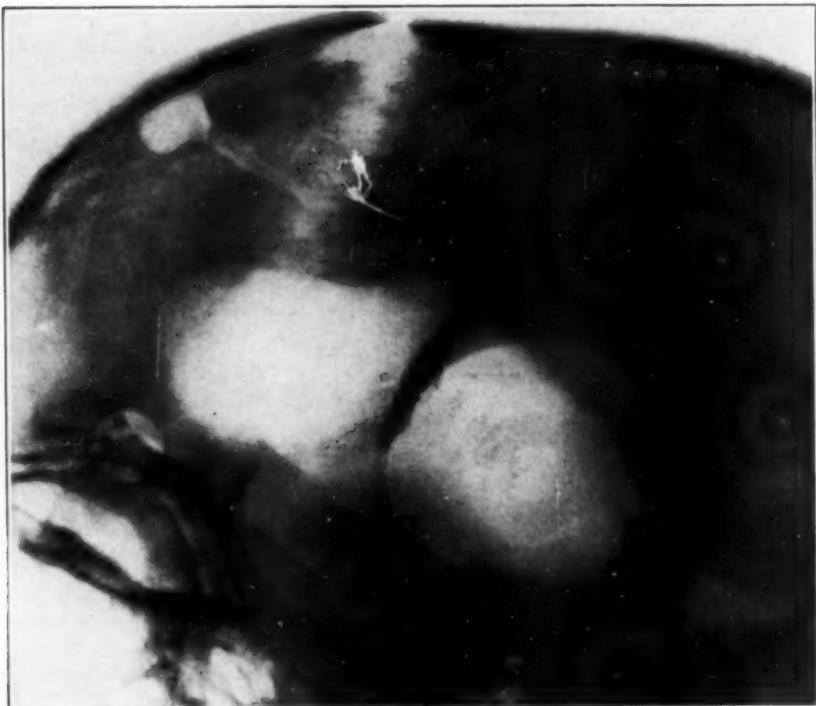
Roentgenogram taken after the cyst cavity in Case 1 had been filled with air. The shadow of the tumor is seen in the bottom of the air-filled space.
